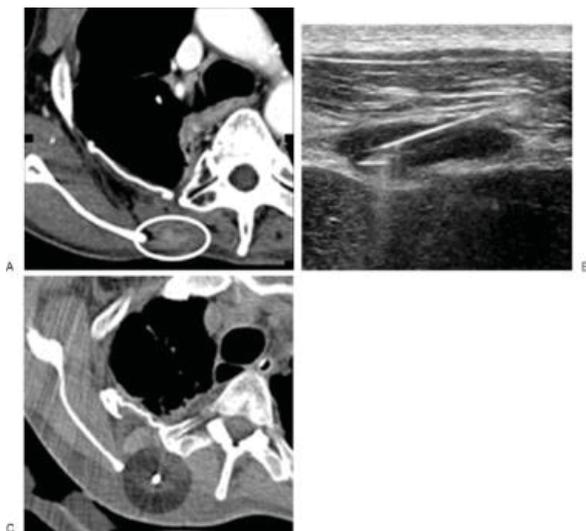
A) Contrast enhanced CT image shows metastatic esophageal sarcoma at the scapula B) Ultrasound image shows cryoprobe placement into the metastases C) Unenhanced CT image shows ice ball encompassing the metastases ^[10]
